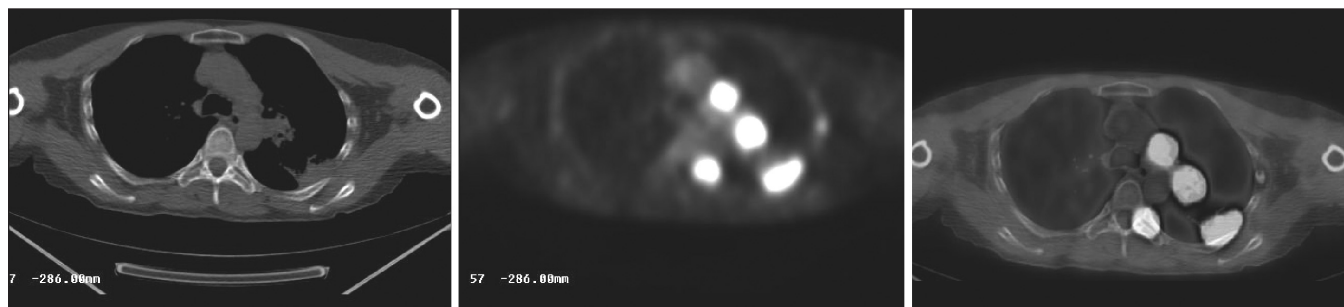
Integrated positron emission tomography/computed tomography scan demonstrating cancer in the left lung with chest wall involvement and metastasis to left hilar and mediastinal nodes and the left thoracic spine and ribs.
